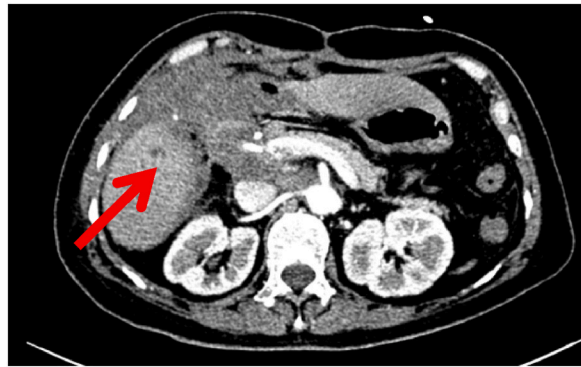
2022.02 Upper abdominal CT without treatment.
